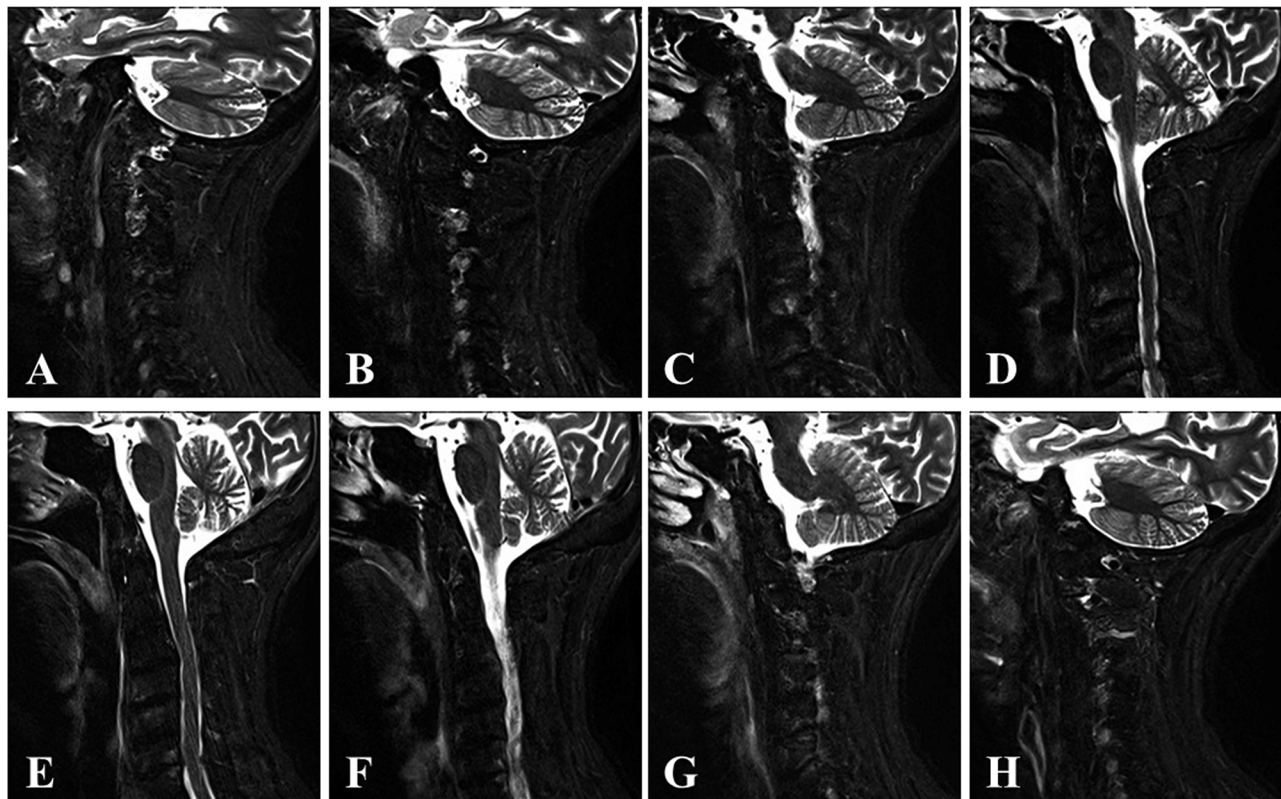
Sagittal T2-weighted MR imaging with fat suppression demonstrates that the T2-hyperintense lesion on preoperative MRI has disappeared 2 weeks after oral administration of non-steroidal anti-inflammatory drugs (A-H; from the right side to the left side).
